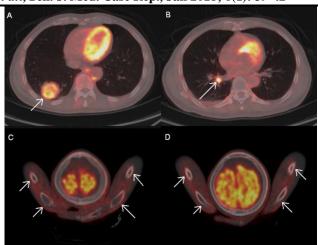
¹⁸F-FDG-uptake in a solid lung tumor in the right lower lobe and lymph node respectively (A-B). No FDG-avidity in periostea of long tubular bones of the upper extremity (C-D).
